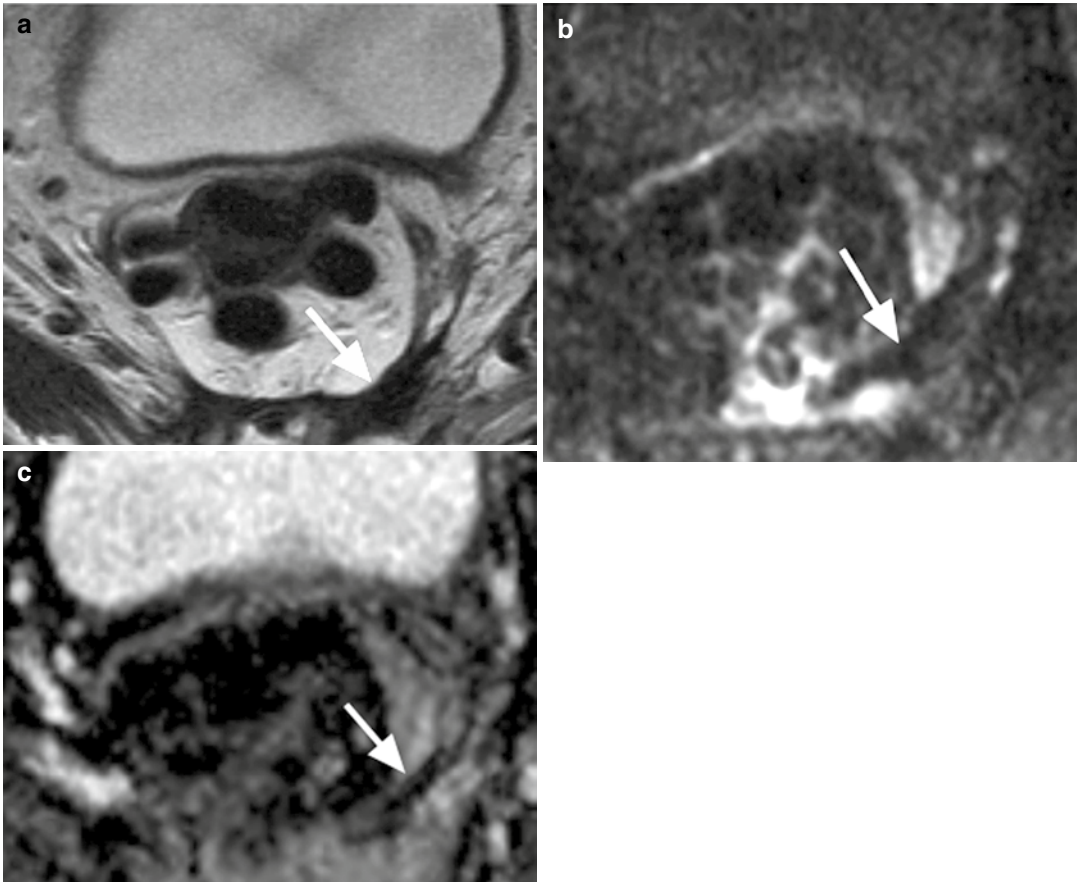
A man with previous low anterior resection for rectal cancer. (a) T2-weighted MRI shows low signal intensity change in the presacral area (*arrow*) consistent
